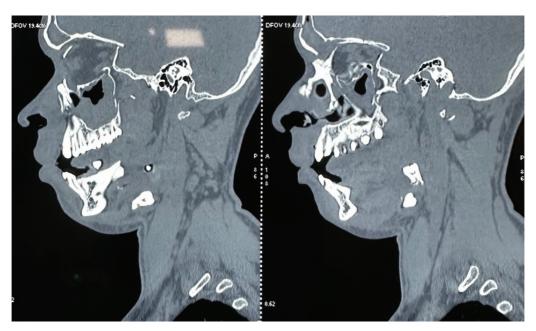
Computed tomography (CT) scan showing dislodged teeth in the submandibular region.
